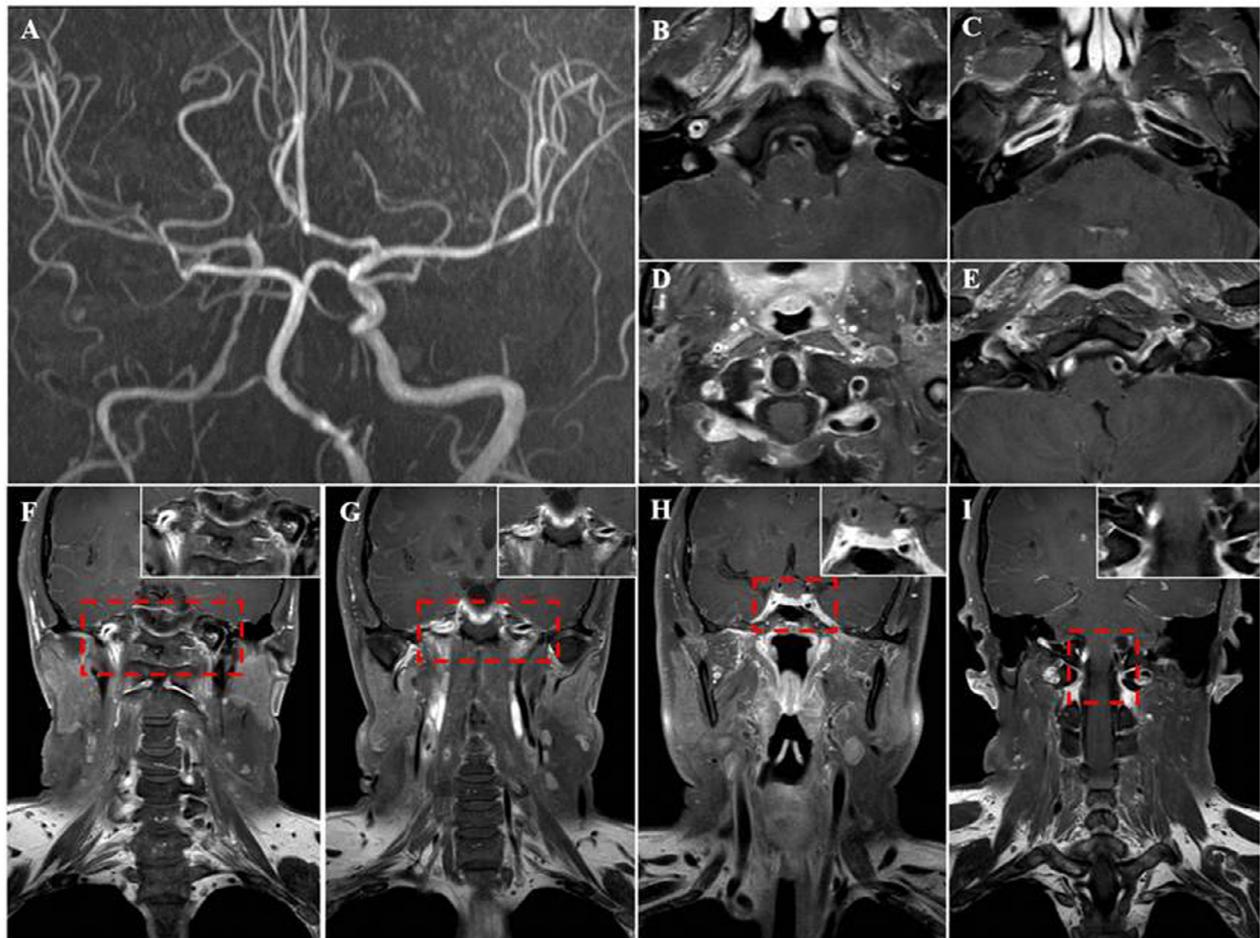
MRA showed diffuse stenosis along the right ICA, the right MCA, and the right vertebral artery. (A) The 3D VW-MRI showed uniform thickness with contrast enhancement of the vessel wall of the right ICA, the right MCA, and the right vertebral artery (B-I). Abbreviations: MRA, magnetic resonance angiography; VW-MRI, Vessel Wall-magnetic resonance imaging. (Color version of figure is available online.)
